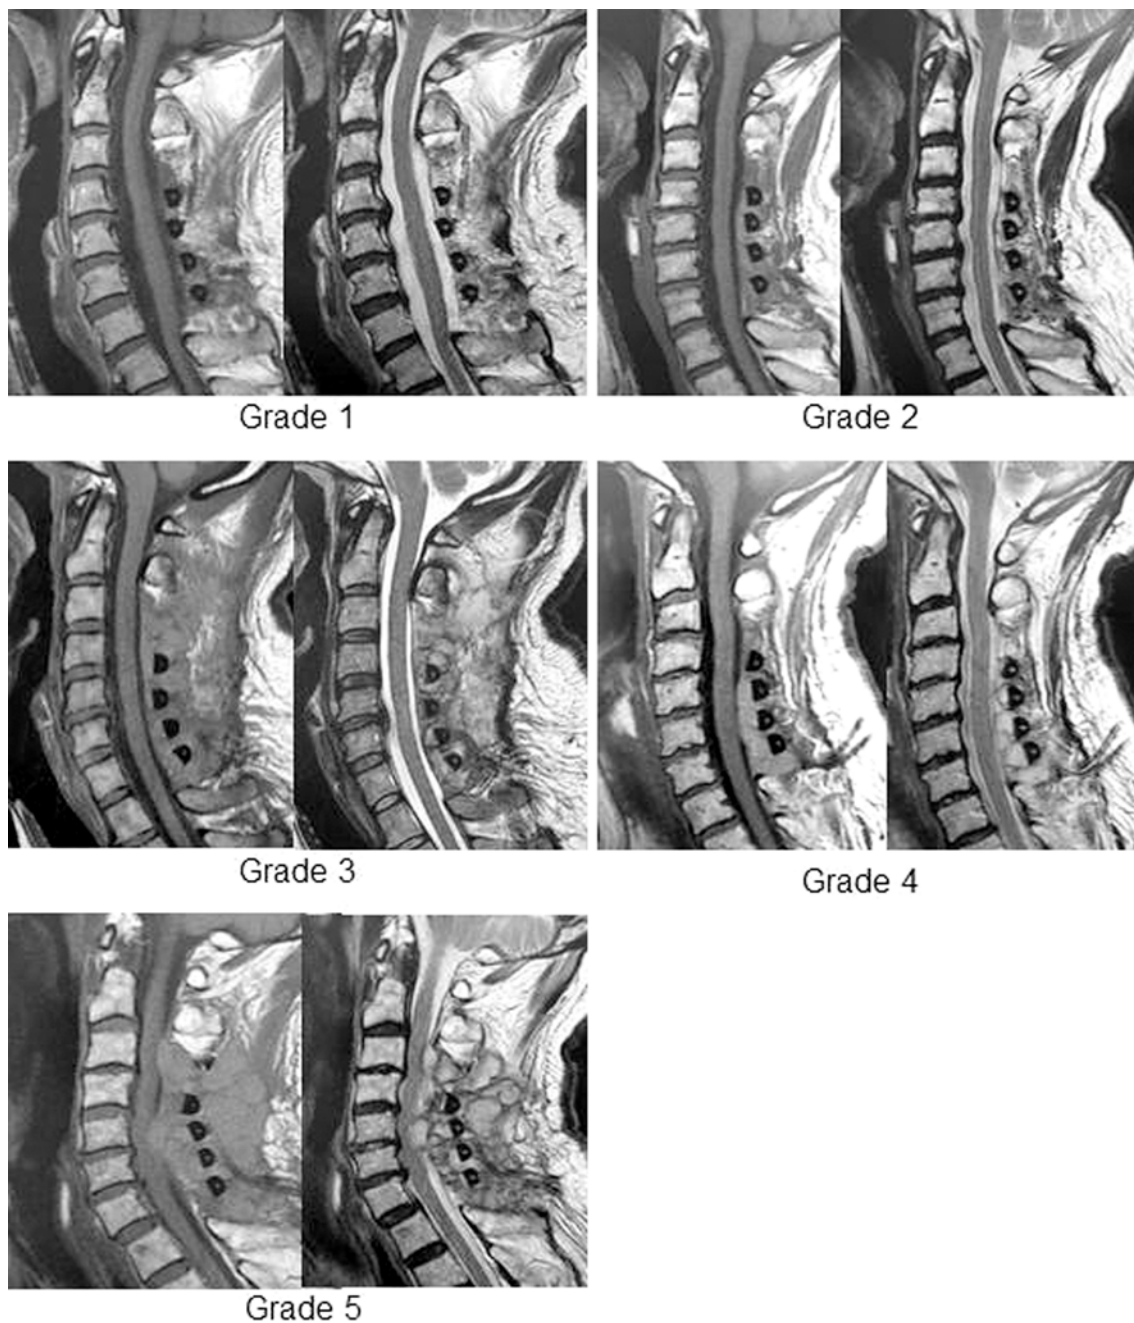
Grading of the mass posterior to the dural sac using magnetic resonance (MR) imaging. T1-weighted (left) and T2-weighted (right) mid-sagittal MR images are shown for each grade. Grade 1: Dorsal dural sac space (DDS) is expanded without any compression by the mass. Grade 2: DDS is expanded with partial compression by the mass. Grade 3: DDS has a linear shape with the entire area compressed by the mass. Grade 4: DDS disappears without compression of the spinal cord by the mass. Grade 5: The spinal cord is compressed by the mass.
